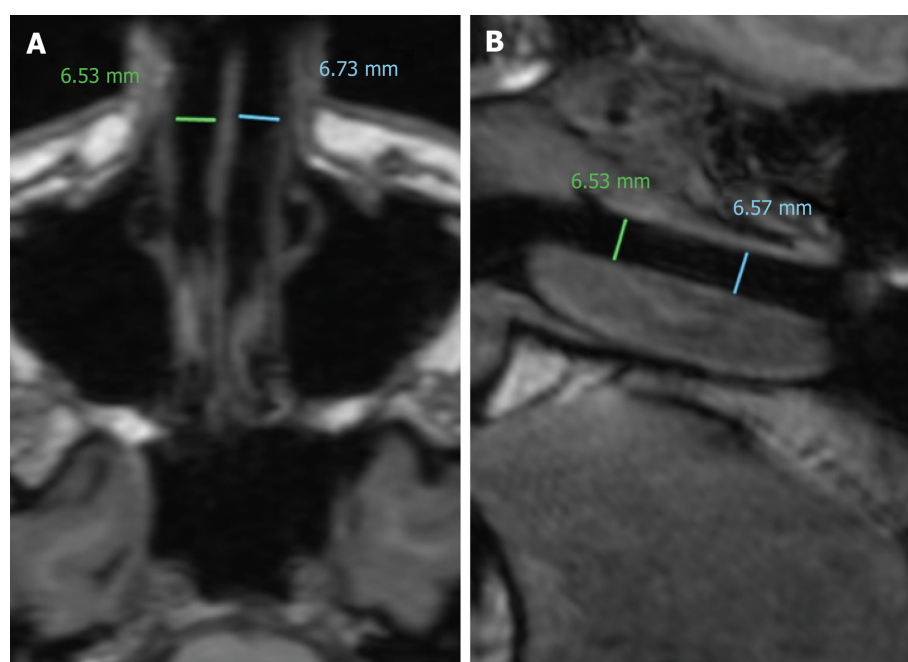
Axial (A) and sagittal (B) magnetic resonance imaging (from September 2018) showing measurements of middle nasal passage with AlaxoLito Xtreme stents *in situ*.
